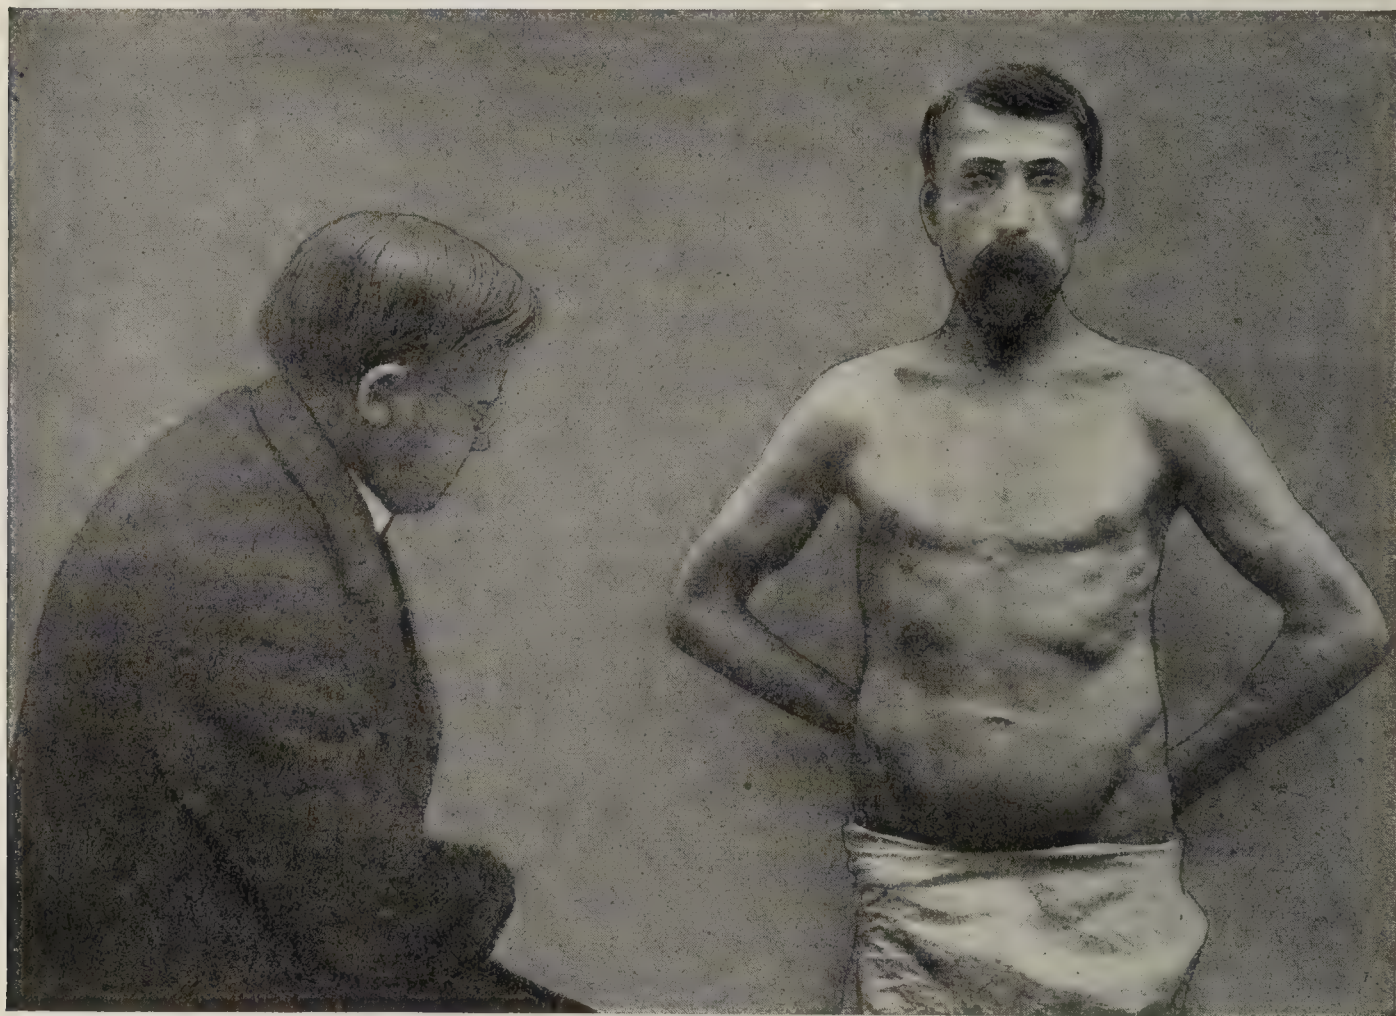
INSPECTION OF ABDOMEN (LATERAL VIEW) TO ASCERTAIN THE MOVEMENTS OF THE CHEST AND ABDOMEN.
